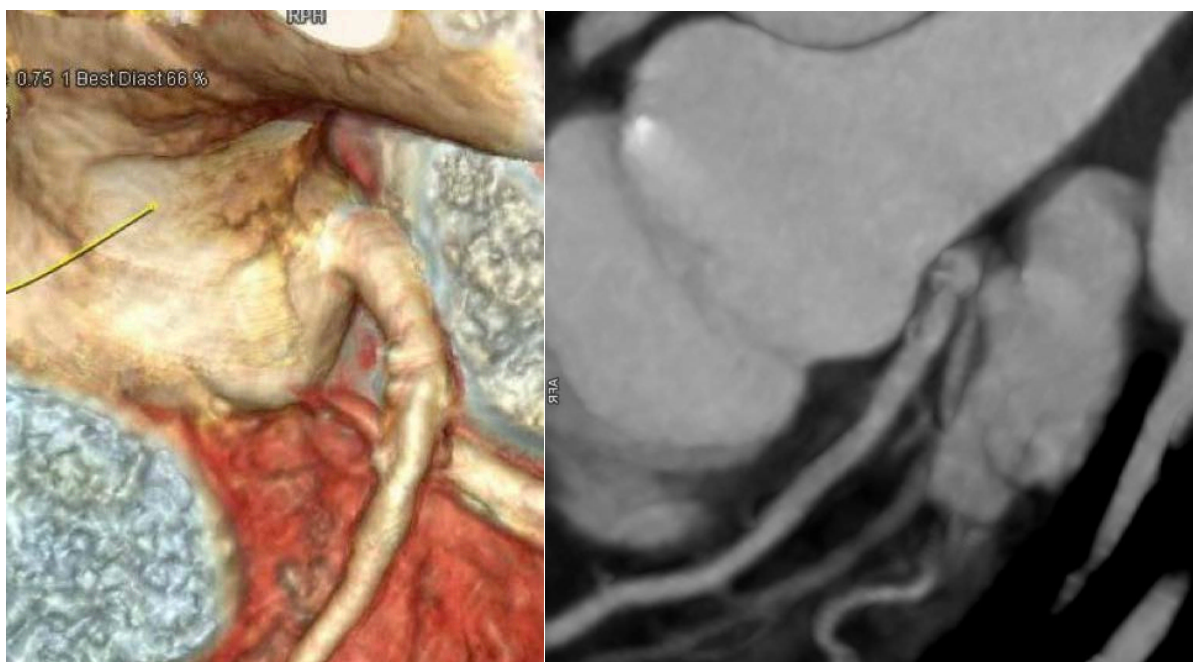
Coronary CTA of left anterior descending artery with old dissection/beaded appearance suggestive for FMD involving the coronary arteries.
